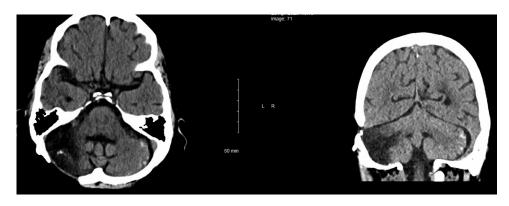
Brain computed tomography showing complete response 9 months after first hypofractionated stereotactic radiation therapy.
